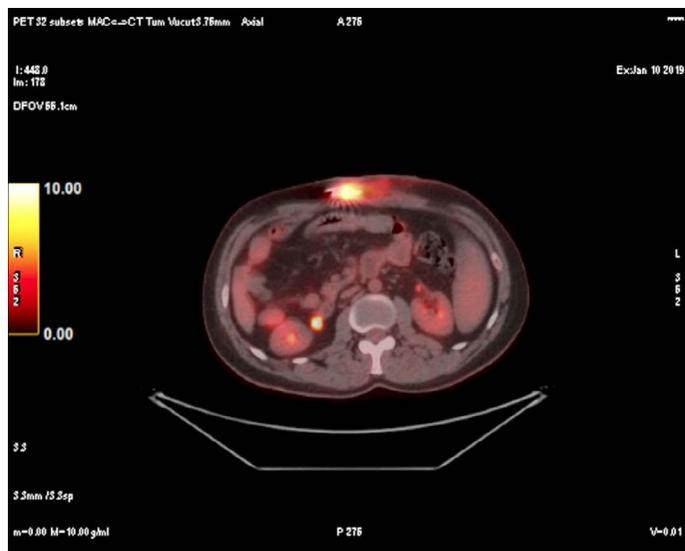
Focal, severe FDG uptake in favor of pump infection.
